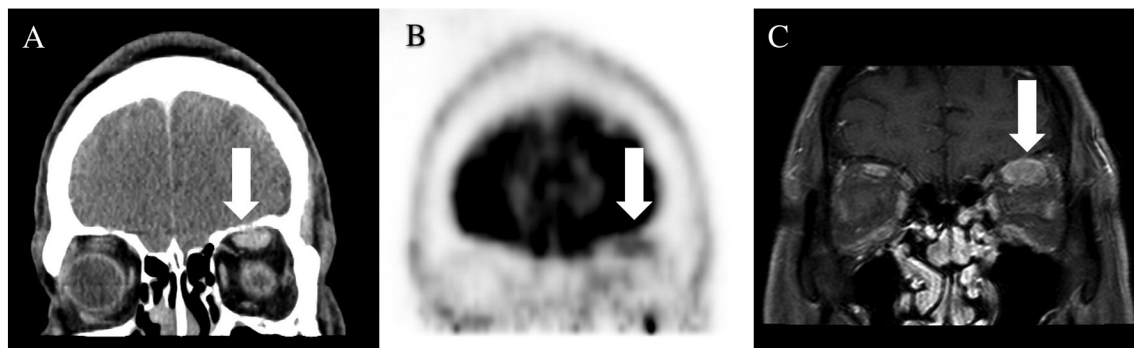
59-year-old man with progressive left eye swelling for 6 months. (A) Coronal contrast-enhanced CT image shows that the left superior rectus muscle is diffusely thickened (white arrow). (B) Corresponding PET image shows focal low grade hypermetabolic activity along the left superior rectus muscle, SUVmax 2.2 (white arrow), in-keeping with lymphomatous infiltration. (C) Coronal contrast-enhanced magnetic resonance imaging (MRI) shows homogeneous enhancement of the thickened left superior rectus muscle (white arrow).
